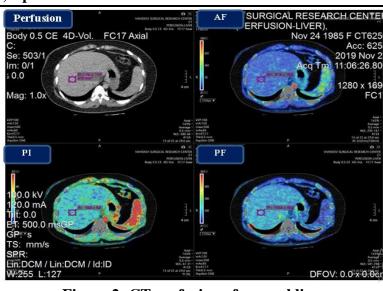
CT perfusion of normal liver
